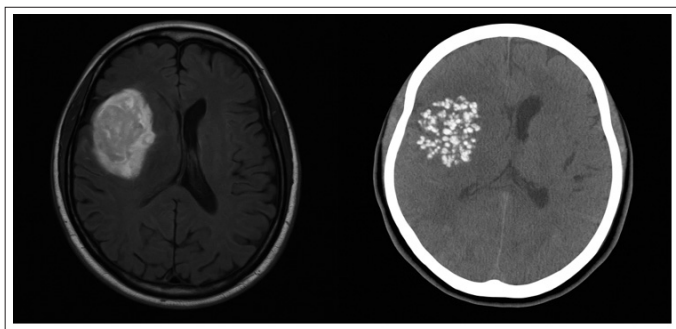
Axial T2-Weighted MRI Showing Hyperintense Mass in Right Frontal Lobe.
